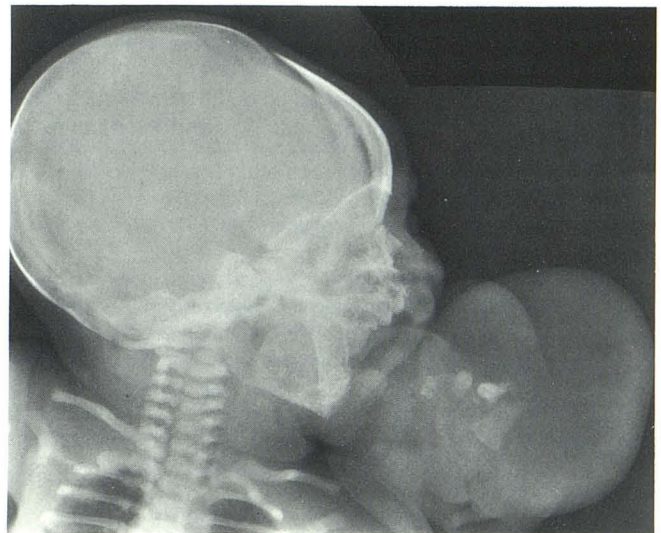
Nasopharyngeal teratoma in another patient. Lateral radiograph shows more typical appearance with teeth.
